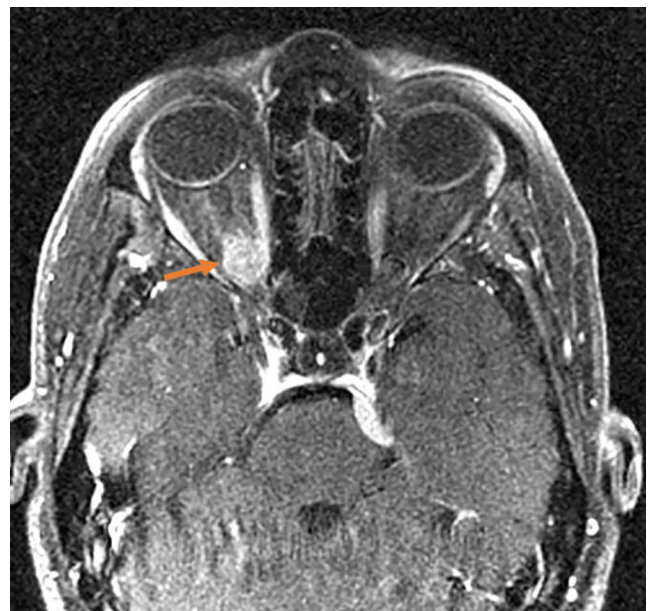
Axial section of a cerebral magnetic resonance imaging with T1 sequence after gadolinium injection revealing a posterior intraconal right orbital lesion process measuring 11 × 9 × 11 mm arriving at the orbital apex, well limited, with regular contours, enhanced moderately and homogeneously after injection of gadolinium (arrow)
